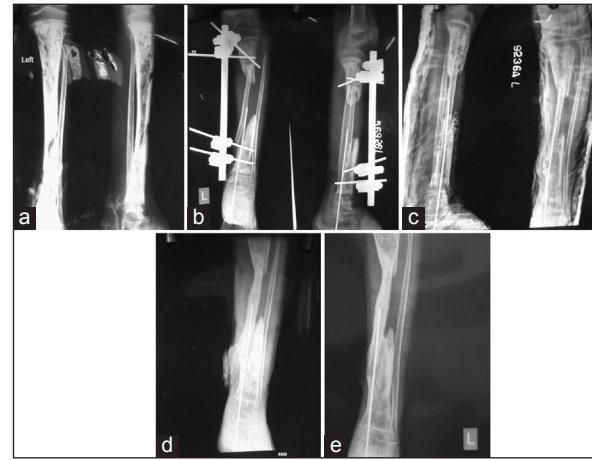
(a) A 16-year-old girl with post-traumatic defect left radius, (b) pre-operative X-ray, (c) 4 months post-operative, patient developed infection at the screw site, which were subsequently removed, (d and e) 6 months post-operative photos
